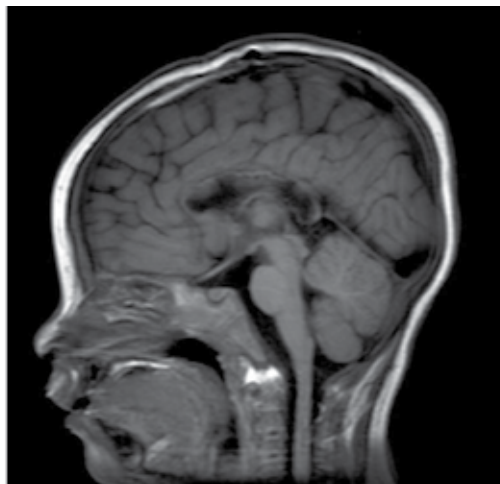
Midsagittal section of MRI Postoperative DTI shows total disconnection of callosal fibers in Fig 3b and misagittal section of MRI confirming total callosotomy.
